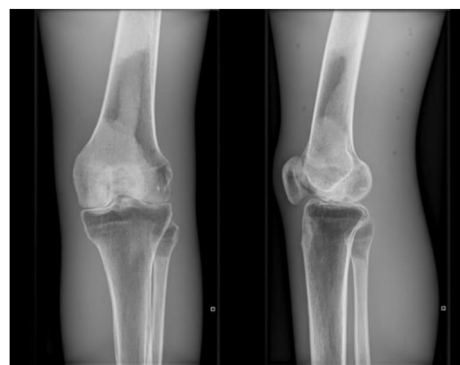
Images produced using the historic 10 kV rule (50 % decreased mAs) AP and Lateral knee X-rays.
